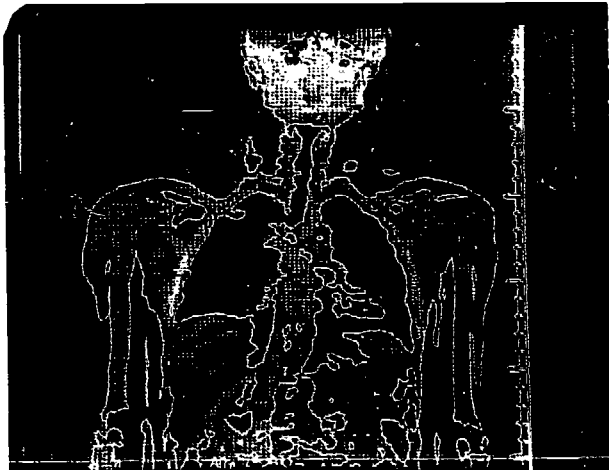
CT-Tomoscan of the lungs in maximum inspiration
